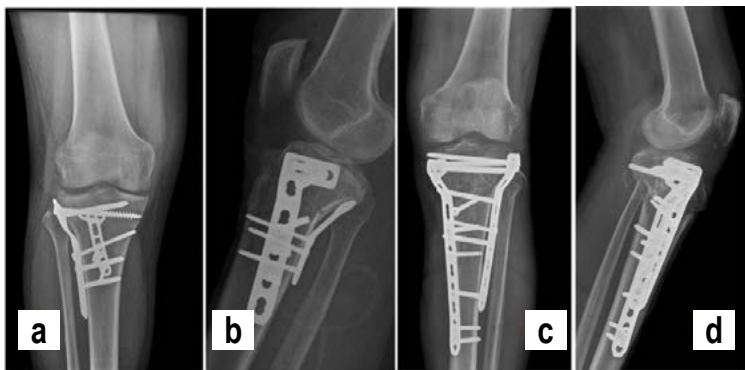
a) anteroposterior radiograph showing the result of direct posterior column fixation performed through a posterior approach to the tibial plateau; b) lateral view of the same patient at two-year follow-up; c) anteroposterior radiograph of a patient treated with indirect posterior column fixation through medial and lateral approaches; d) lateral view showing that no posterior buttress plate was used
